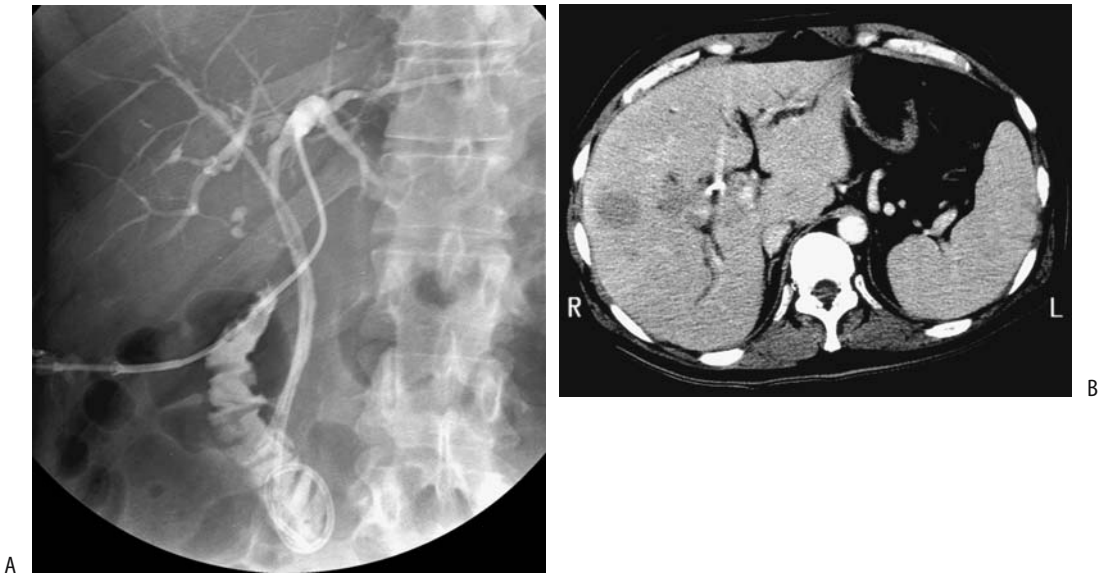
Jaundice due to liver non-Hodgkin's lymphoma. A: A cholangiogram reveals a biliary drainage catheter in place and numerous narrowed intrahepatic bile duct segments. B: A contrast-enhanced CT image shows several focal hypodense tumors. Other images identified intrahepatic tumor tracking along portal vessels. (Courtesy of Patrick Fultz, M.D., University of Rochester.)
